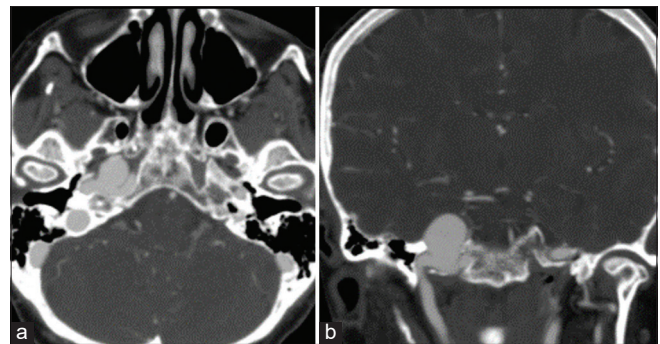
A 67-year-old man with right carotid aneurysm. (a) Axial computed tomography angiogram image with coronal multiplanar reformation (b) shows presence of a large aneurysm involving the petrous segment of right internal carotid artery. There is associated bony remodeling with intracranial extension through the petrous roof.
